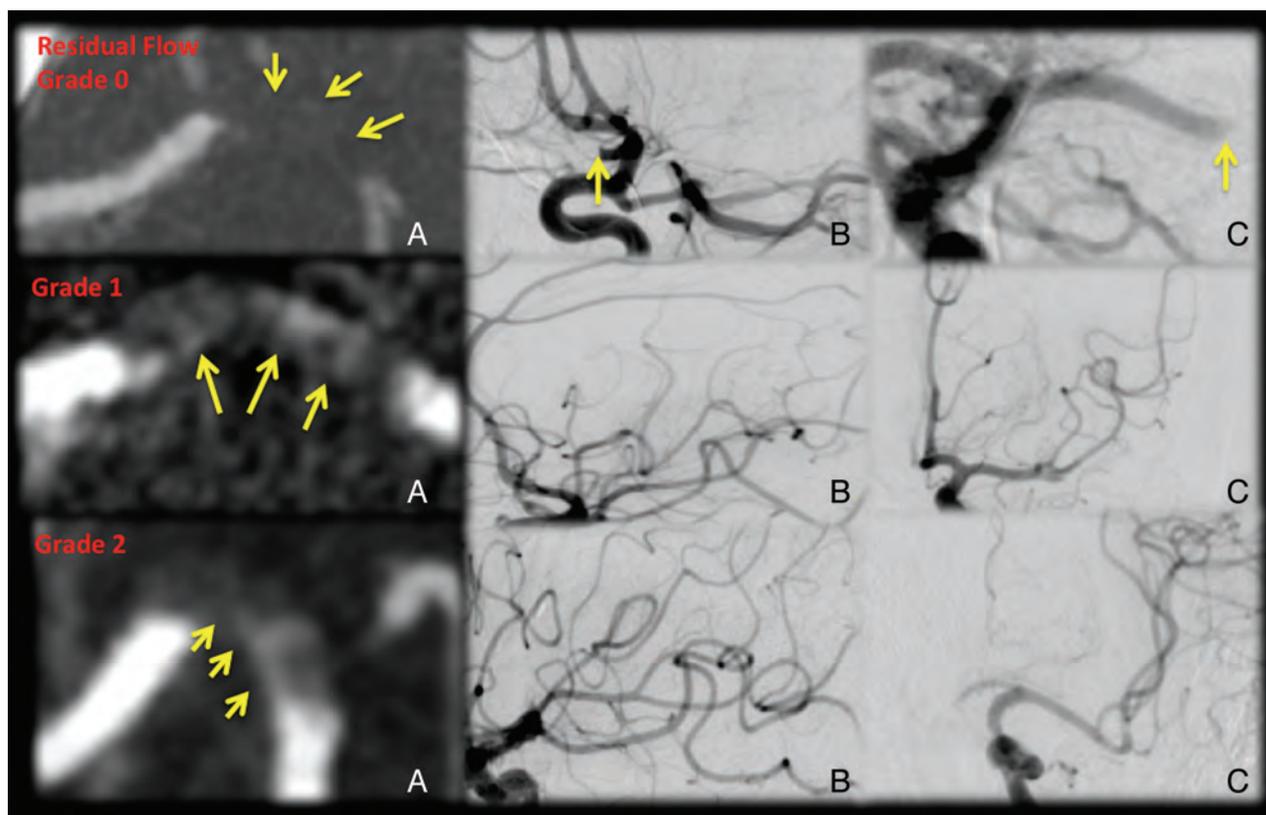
Residual flow on baseline CT angiography along with early reperfusion with IV tPA assessed on the first angiogram of the ipsilesional arterial tree. The top panel shows a patient with a left M1 MCA clot and no residual flow (A, grade 0 residual flow, yellow arrows, density similar to that of surrounding brain parenchyma). The first angiogram shows no recanalization (B and C). The middle panel shows a left M1 MCA clot with grade 1 residual flow (A, yellow arrows, denser than surrounding brain parenchyma). The first angiogram shows excellent reperfusion (B and C). The bottom panel shows a left M1 MCA clot with grade 2 residual flow (A, yellow arrows, hairline or streak of well-defined contrast across the partial or complete length of the clot). The first angiogram shows excellent reperfusion (B and C).
